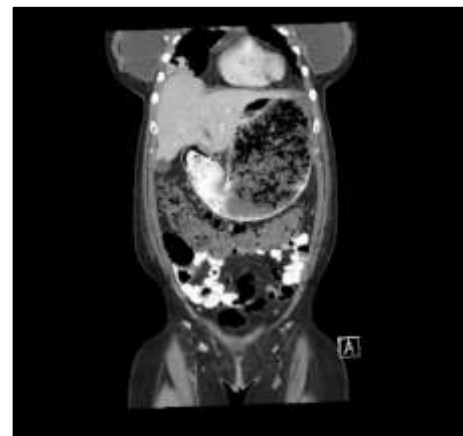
CT results day 1 of admission.
